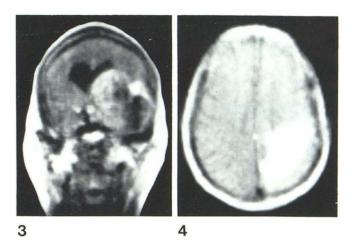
Coronal NMR scan. Epidermoid in middle cranial fossa. Areas of high signal in tumor corresponded to areas of negative CT attenuation. Fig. 4.—Axial transverse NMR scan. Left-sided parietal hematoma.
